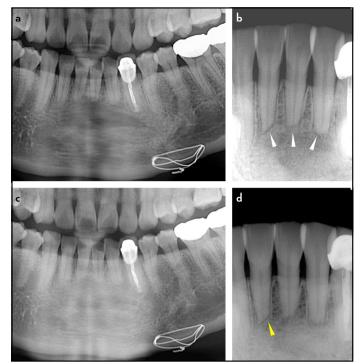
Radiographic features on follow-up examinations. (a) 1-year follow-up panoramic and (b) periapical radiographs. Note the resorbed apical portion of the roots (white triangles). (c) 4.5-year follow-up panoramic and (d) periapical radiographs. Complete bony healing was verified, and the root resorption did not progress further. The periodon-tal ligament space was seen as a narrow radiolucency between the root and the lamina dura (yellow triangle)
